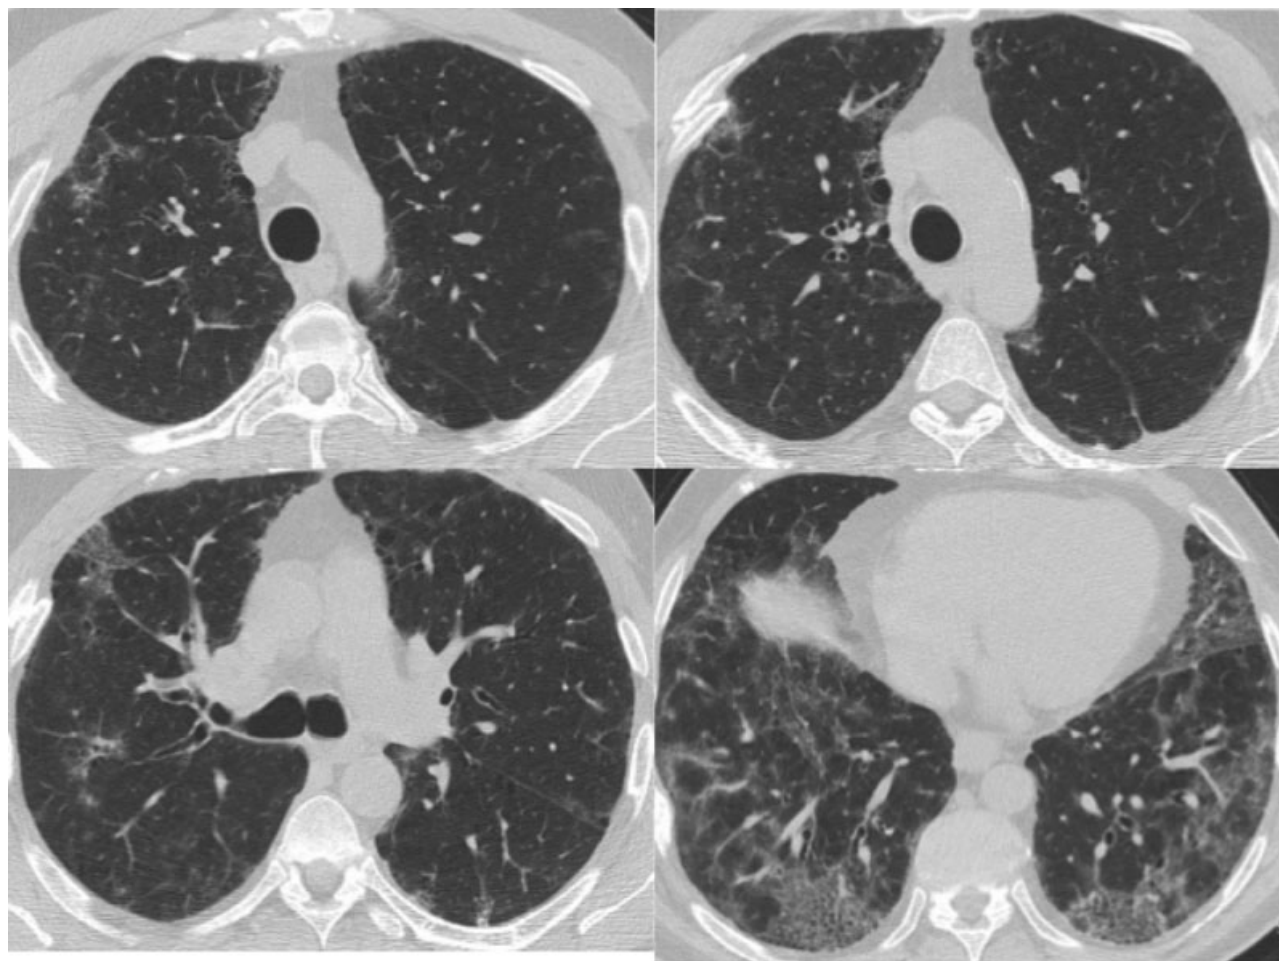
HRCT findings of fibrotic NSIP in a former smoker. A moderate ground-glass attenuation associated with a mild reticulation is visible in both lower lobes with a prevalent peripheral distribution. Traction bronchiectasis is also present. Paraseptal emphysema is present in both upper lobes.
